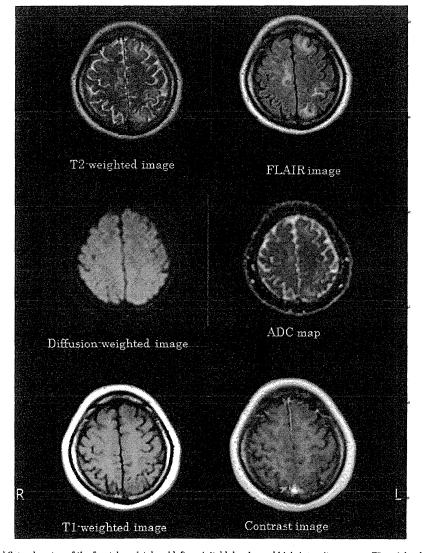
Brain MRI on admission: bilateral cortex of the frontal, parietal and left occipital lobe showed high-intensity areas on T2-weighted, FLAIR and ADC images, iso- or hyperintense areas on DWI, but low-intensity areas o T1-weighted image. In contrast image, lesion was not enhanced.
